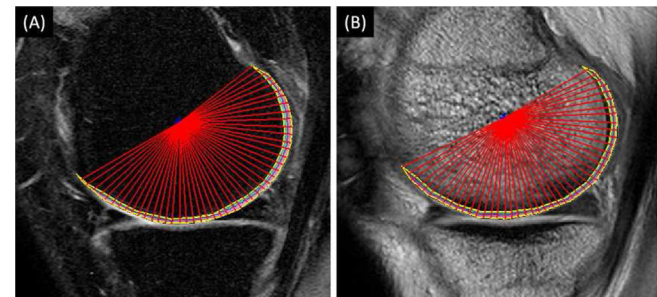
Sagittal images from T1rho sequence of knee MRI after manual segmentation with post-processing. (A) SPGR (B) b-FFE.
